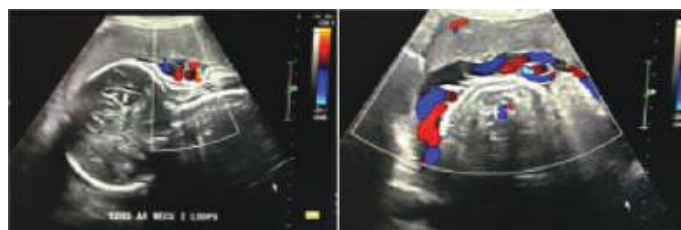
Obstetric Doppler showing double loop of cord round the neck
